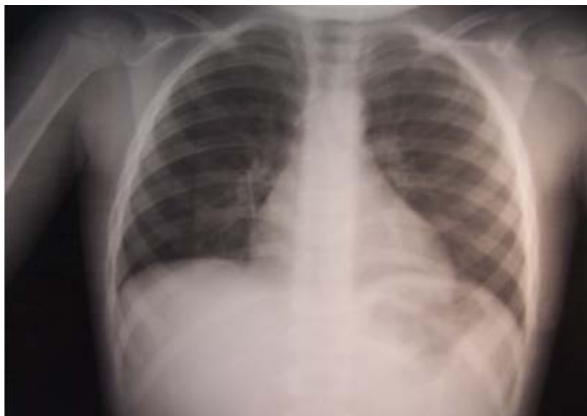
Plain thoracic x-ray shows straight pin in the first patient.
